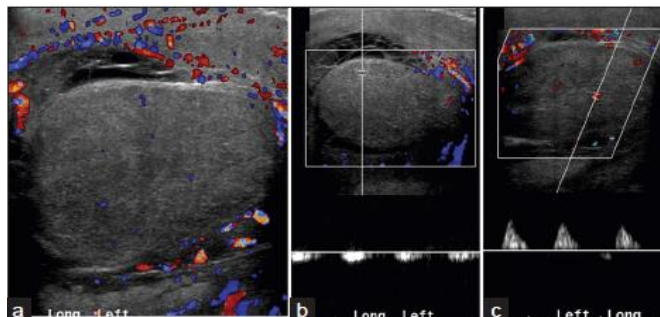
A 22-year-old male with epididymo-orchitis on antibiotics. (a) Color flow Doppler demonstrates an enlarged, edematous testis with decreased blood flow. (b) Pardon waveforms and (c) monophasic waveform in the same testis confirm high resistance to arterial inflow secondary to significant testicular edema.
